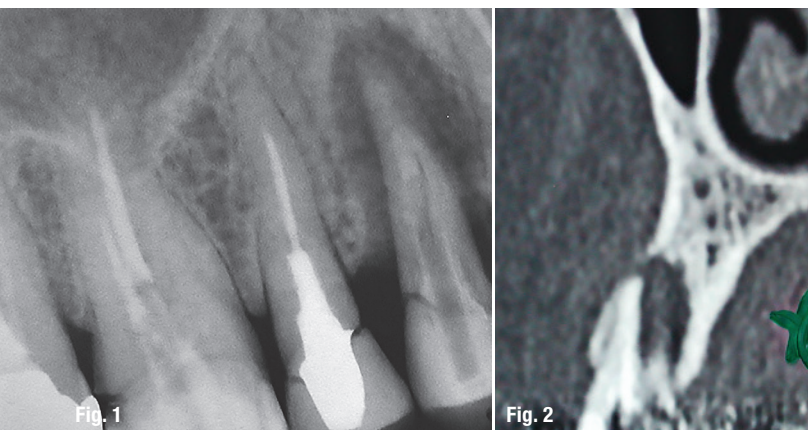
Pre-op radiograph showing a fractured root. Fig. 2: A cyst had developed around the fractured tooth. Fig. 3: The extracted tooth in two pieces. Fig. 4: Preparation of the surgical site. Fig. 5: The cavity after extraction of the tooth.
